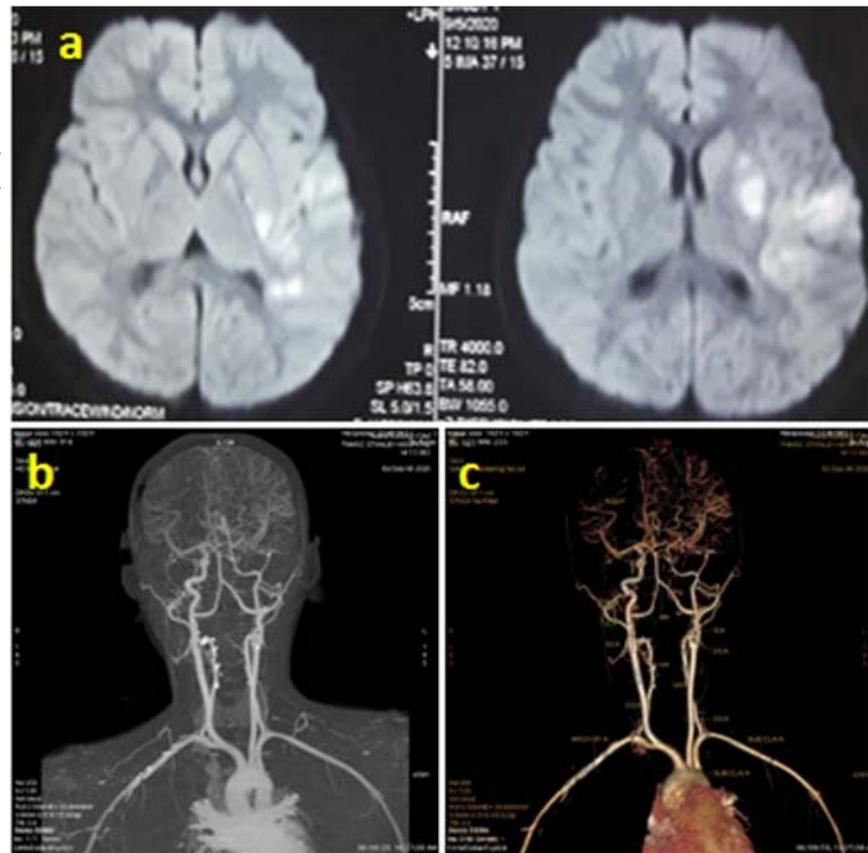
(a) MRI DWI Image showing acute infarct in left post central gyrus, corona radiata, posterior limb of internal capsule and insular cortex; (b) CT angiogram Revealed complete occlusion of left ICA with reformation of left anterior cerebral artery and middle cerebral artery; (c) DSA revealed narrowing of distal left ICA with multiple collaterals and complete occlusion of left MCA. Right MCA and bilateral ACA and its branches were opacified
